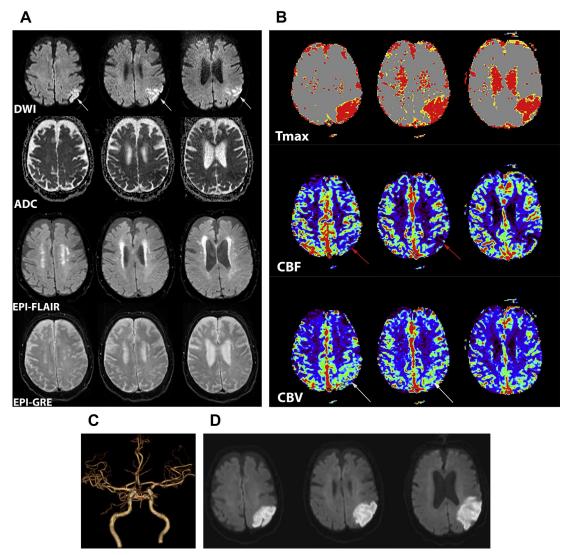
A 58-year-old man with past medical history of atrial fibrillation hypertension, presents with right-sided weakness. Baseline NIHSS: 6. Time of onset to first MR imaging was approximately 90 minutes. Using the 6-minute MR stroke protocol, there is a hyperacute infarction involving left posterior frontal and parietal lobes (A) (white arrows on DWI images). Note the absence of FLAIR hyperintense signal, which is suggestive of hyperacuity. There is no hemorrhage on EPI-GRE images. There is a larger perfusion deficit (so-called diffusion-perfusion mismatch) best seen on DSC-T<sub>max</sub> greater than 6 seconds (B), which is suggestive of critical delayed perfusion. There is regional increased CBV (white arrows) caused by increased autoregulation, which seems inadequate because there is decreased CBF (red arrows). MRA (C) shows no proximal arterial stenosis. On follow-up MR imaging (D) obtained 12 hours later, there is progression and growth of infarction now encompassing the entire hypoperfused region detected on the initial MR imaging.
